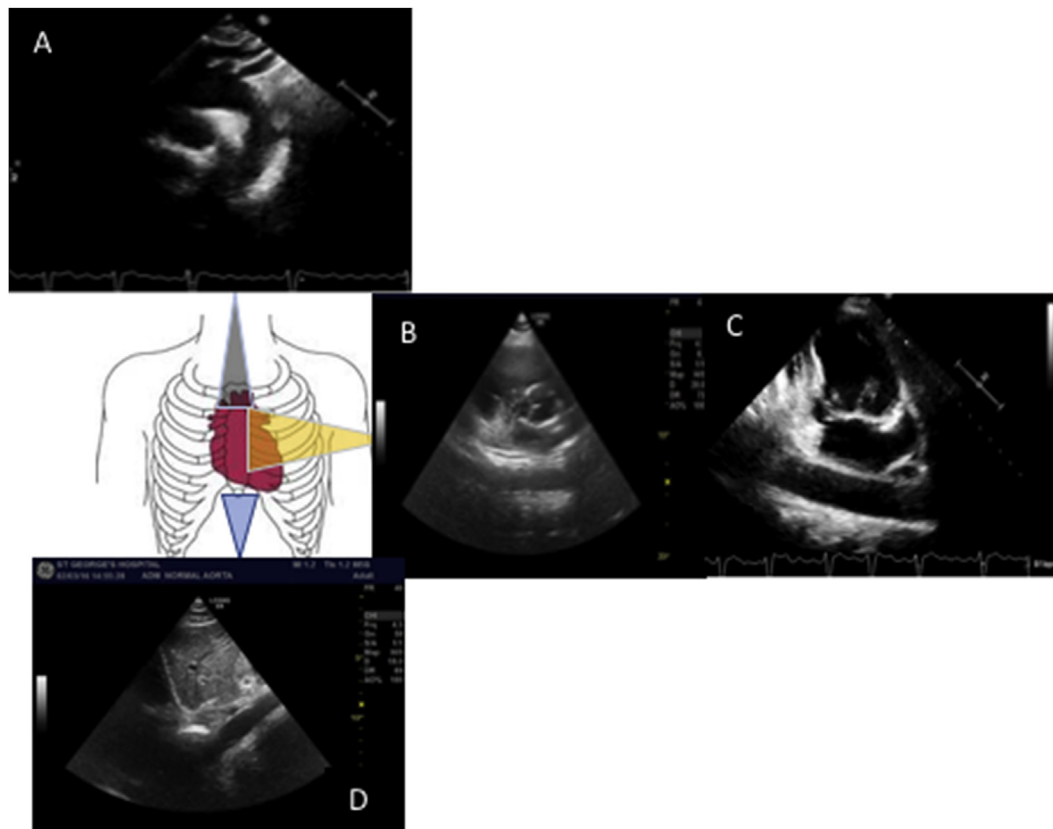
Main acoustic windows used in this study to assess the aortic arch and descending thoracic aorta. (A) Suprasternal window. The aortic arch and the three major supra-aortic vessels can be visualised with this window. (B) Longitudinal view of the aorta in parasternal long axis window. To obtain a longitudinal view of the mid descending thoracic aorta, modification of the standard parasternal long axis view was used; the transducer was rotated by 90°. (C) Apical two chamber views of the descending aorta (longitudinal views of the aorta). (D) Subcostal view. The distal end of the thoracic aorta and proximal segment of the abdominal aorta are visualised in this window.
